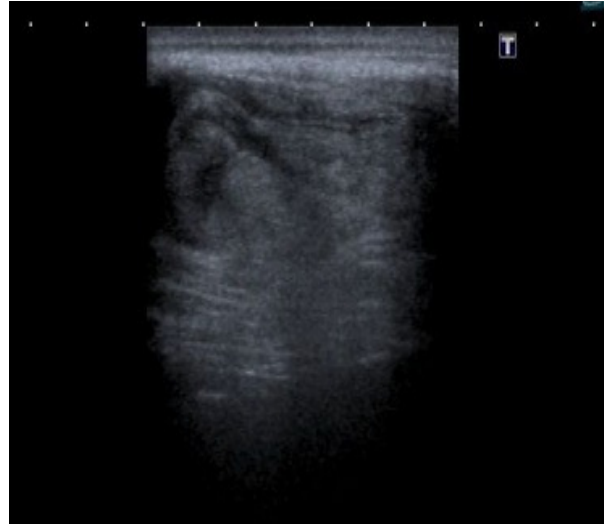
Review ultrasound which was done immediately after CECT and 24r hours from initial US, showed that the cystic lesion was sub totally filled with echogenic fat.
